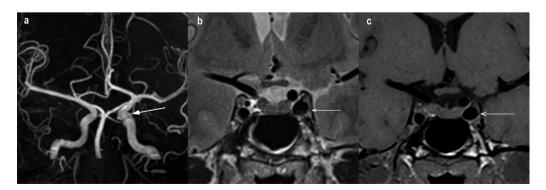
Moderate dilatation of the cavernous segment of the left ICA on collapsed MRA (arrow). On high resolution T2-weighted coronal and enhanced T1-weighted coronal images, conflict between left ectatic ICA and ophthalmic nerve is present (b, c, arrows).
